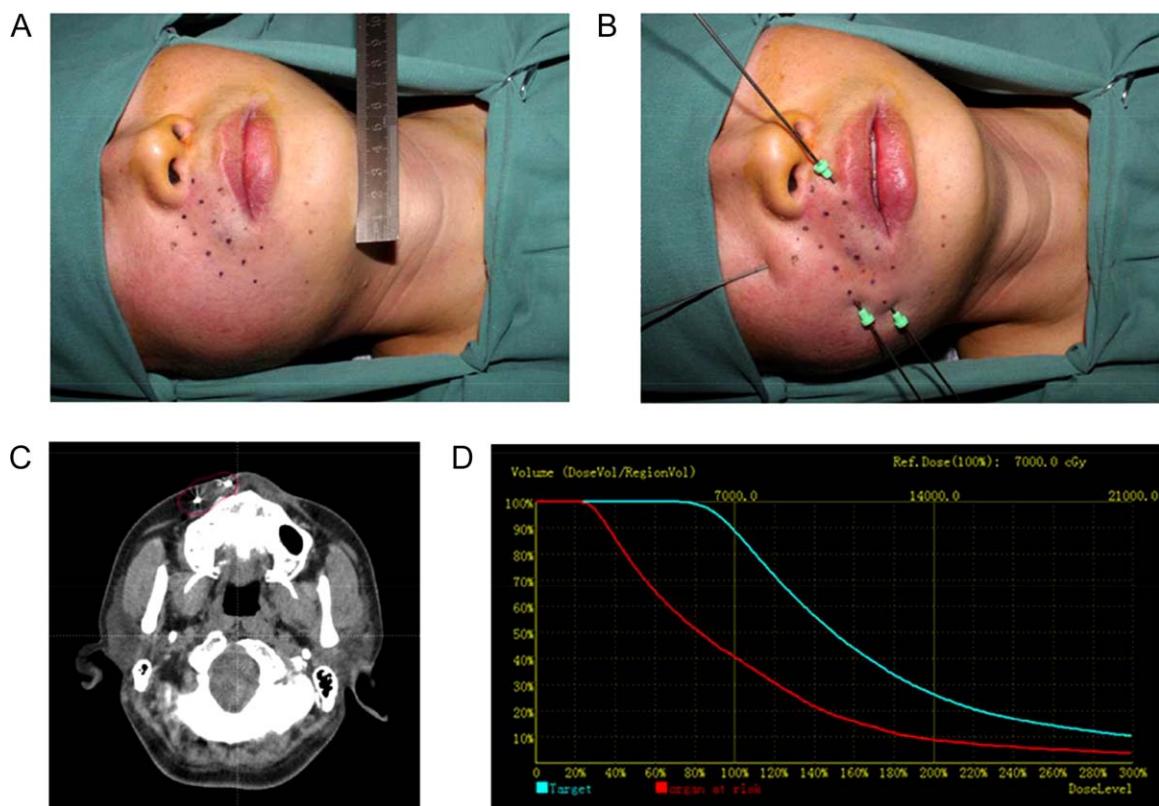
(A, B) Hollow interstitial needles were inserted into the target area and iodine-125 radioactive seeds were implanted permanently 1 cm apart in a single layer of lip and buccal according to the plan. (C) Postoperative CT images in the brachytherapy treatment planning system. (D) Dose-volume histogram of quality verification. [Color figure can be viewed at wileyonlinelibrary.com]
